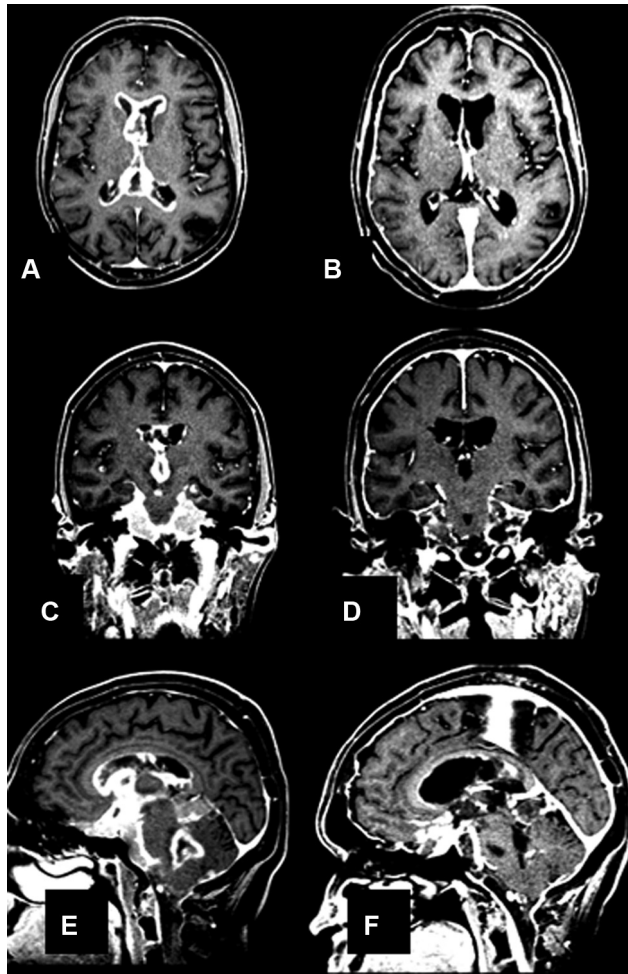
T1-weighted magnetic resonance imaging with gadolinium pre and posttreatment. Partial remission of the tumor in response to radiotherapy plus procarbazine, lomustine, and vincristine (PCV) chemotherapy. The nodular and thick gadolinium enhancement observed on pretreatment T1-weighted magnetic resonance imaging (A, C and E) became thinner and less intense 3 months after the treatment (B, D and F).
